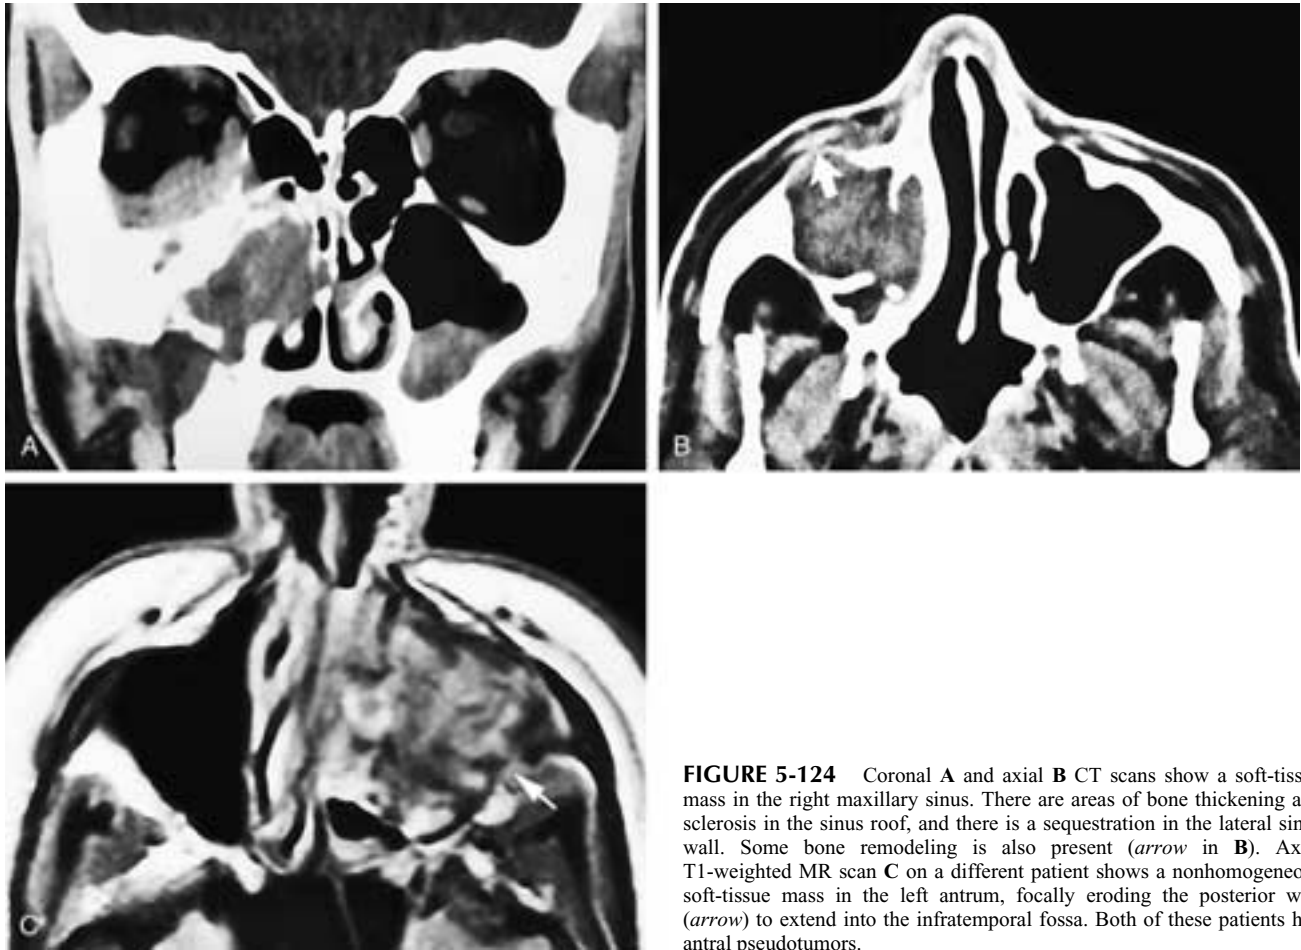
Coronal A and axial B CT scans show a soft-tissue mass in the right maxillary sinus. There are areas of bone thickening and sclerosis in the sinus roof, and there is a sequestration in the lateral sinus wall. Some bone remodeling is also present (*arrow* in B). Axial T1-weighted MR scan C on a different patient shows a nonhomogeneous soft-tissue mass in the left antrum, focally eroding the posterior wall (*arrow*) to extend into the infratemporal fossa. Both of these patients had antral pseudotumors.
